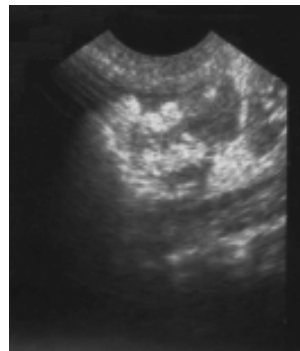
A sagittal ultrasonographic image of the left, cranial, abdominal mass in a two-year-old, female squirrel, in dorsal recumbency. A 2.6 by 3.4 -cm, well-defined mass, with smooth echogenic border, was located in the abdominal wall, just cranial to the left kidney position. There were several large hyperechoic areas within the hypoechoic center.
